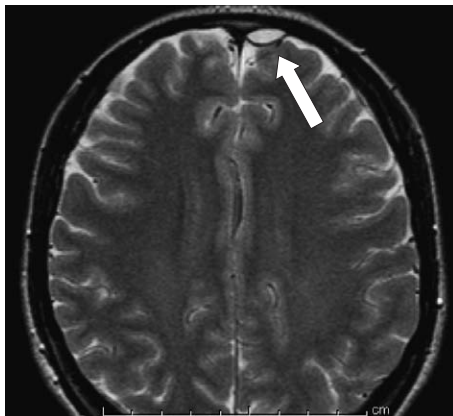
T2-weighted MRI obtained on April 1 showed a high intensity area in the left frontal tip (white arrow).
